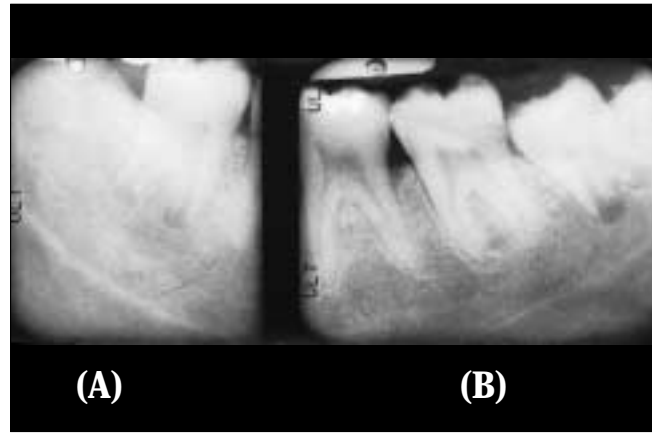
Periapical radiographs of the lower third molars show that root development of tooth 48 (a) appears greater than two-thirds; therefore, tooth 38 (b) was used as the donor tooth.
